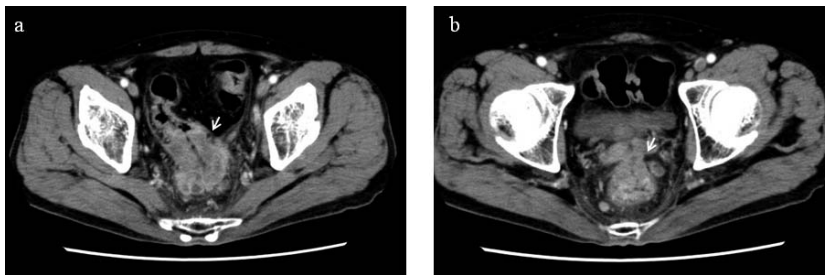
Computed tomography (CT) revealed the rectum tumor (a) that was contiguous with the seminal vesicle and bladder (b). Arrow indicates advanced rectal cancer.
